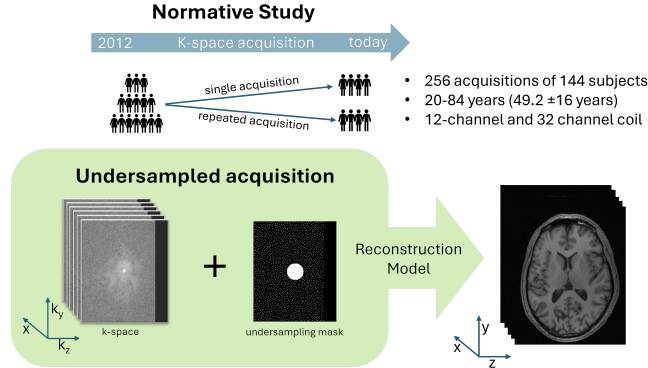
Overview of the CC 2.0 dataset: 3D T1-weighted brain MR imaging scans were acquired using 12-channel and 32-channel coils of single-subject acquisitions as well as repeated subjects. K-space data is provided along with the metadata, enabling undersampled reconstruction benchmarking, coil generalization experiments, and repeat/longitudinal reconstruction analysis.
